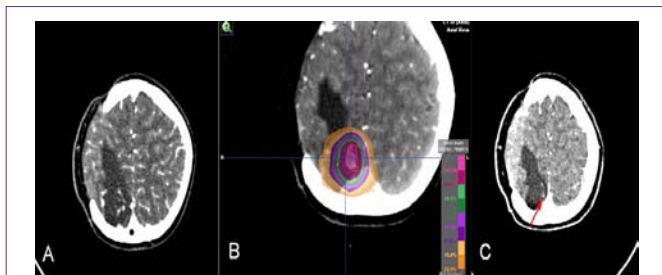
Appearance the arteriovenous malformation before radiosurgery (A) During treatment planning (B) The isodose distribution is shown in color wash, and after radiosurgery (C) On the CT angiography only a draining vessel (red arrow) is visible.
